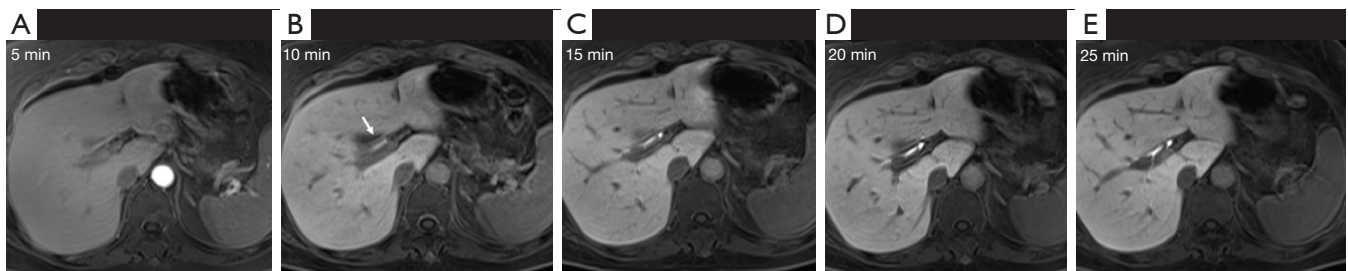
A female non-cirrhosis patient, 45 years old, 5 HCPs acquired with a time interval of 5 min from 5 to 25 min (A-E) after the Gd-EOB-DTPA administration. Two radiologists with 8 and 10 years of experience in abdominal MRI diagnosis both identified 10 min (B) as the initial intrahepatic bile duct visualization (white arrow) and so 15 min (C) as HCP_{proposed}. Two months later, the same 2 radiologists identified 15 min (C) and 20 min (D) as HCP_{EC}, respectively, and the third radiologist arbitrated the HCP at 15 min as the HCP_{EC}. HCP, hepatocyte phase; Gd-EOB-DTPA, gadoteric acid disodium; MRI, magnetic resonance imaging; HCP_{proposed}, the HCP acquired 5 min after the initial visualization of the intrahepatic bile ducts; HCP_{EC}, adequate HCP determined upon the 2016 Expert Consensus of the European Society of Gastrointestinal and Abdominal Radiology.
